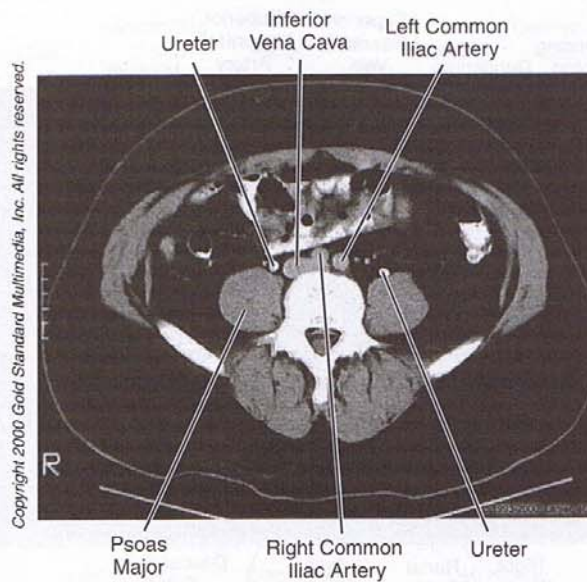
Abdomen: CT, L₄
